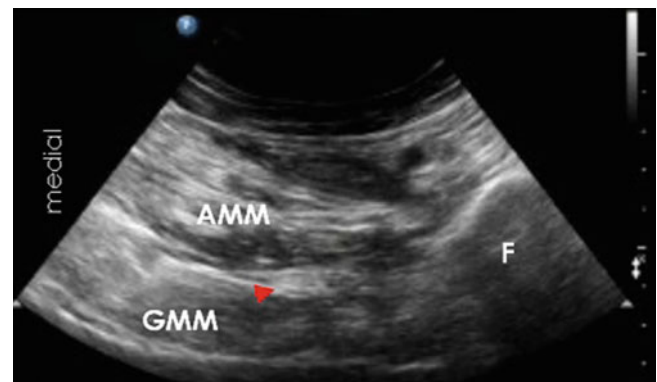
Anterior approach sonographic appearance. *AMM* adductor magnus muscles, *GMM* gluteus maximus muscle, *F* femur. The sciatic nerve is indicated by the *arrow* (Figures are reproduced with permission of www.USRA.ca)
